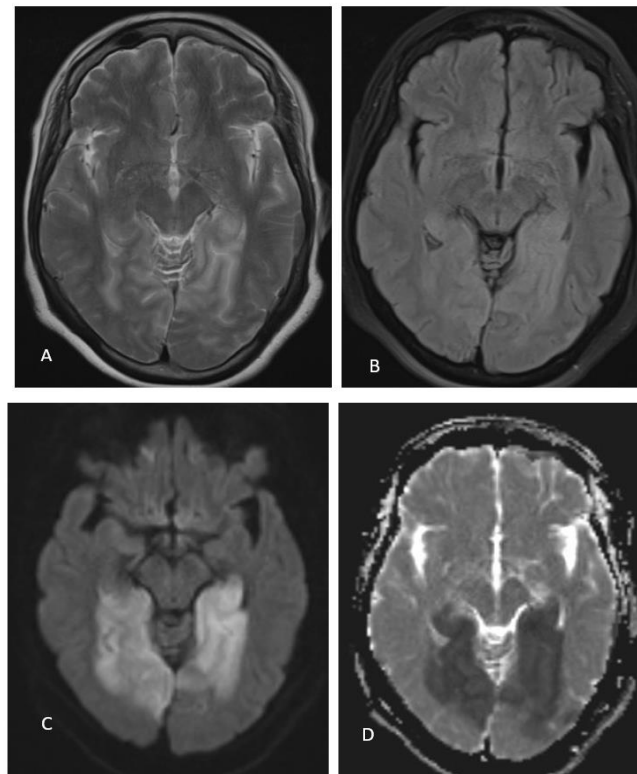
MRI in axial sections, T2 (A), flair (B), and diffusion (C) sequences showing the presence of a high signal with low Apparent Diffusion Coefficient (ADC) (D) in the occipital lobes
